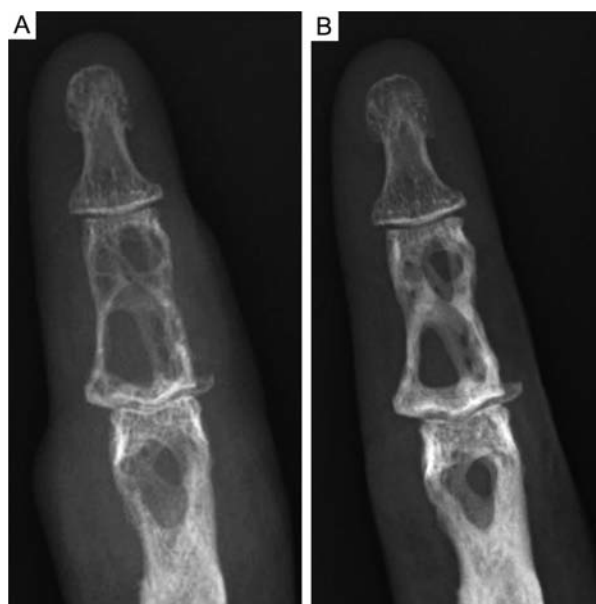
Radiographs of right hand forefinger before (A) and one year after (B) the administration of ITCZ. Multiple cystic lesions gradually reduced with marked improvements in both density and thickness of the bone cortex. A remarkable swelling of soft tissue also improved.
